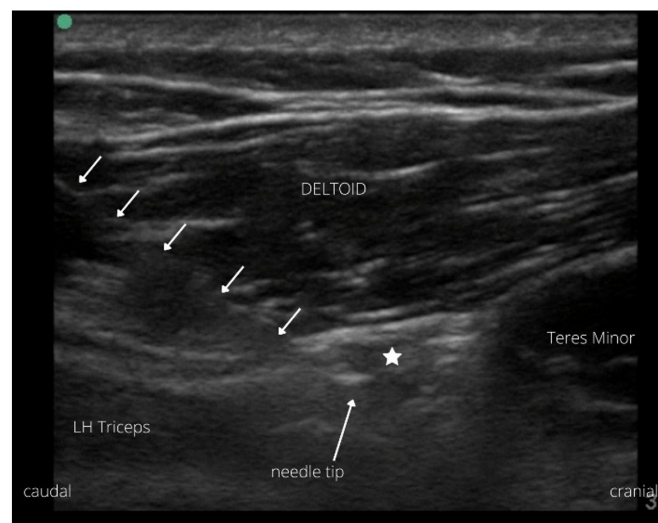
Ultrasound guided pulsed radiofrequency needle placement “in-plane” in the quadrilateral space just below the axillary nerve (star) confirmed by sensory and motor stimulation.
